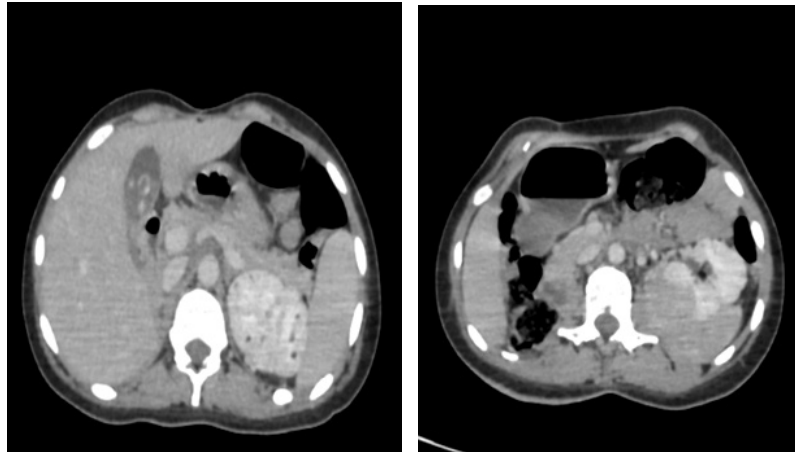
Abdominal CT scan in axial slices at portal phase showing a large exophytic mass in the left kidney with vascular structures and fat areas, suggestive of an angiomyolipoma. Multiple millimetric fat-density formations are also present in the renal parenchyma.
